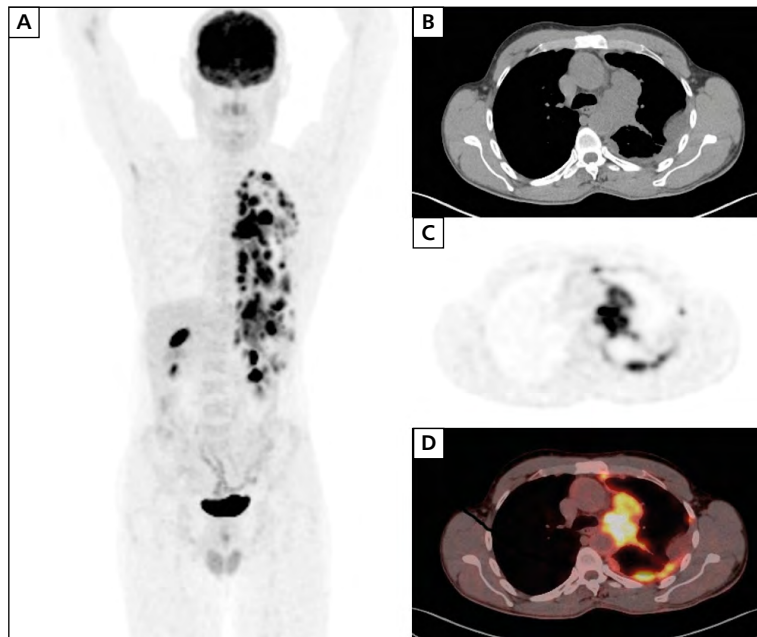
Pre-treatment imaging; A. Maximum intensity projection (MIP); B. Computed tomography; C. Positron emission tomography; D. Fusion images
